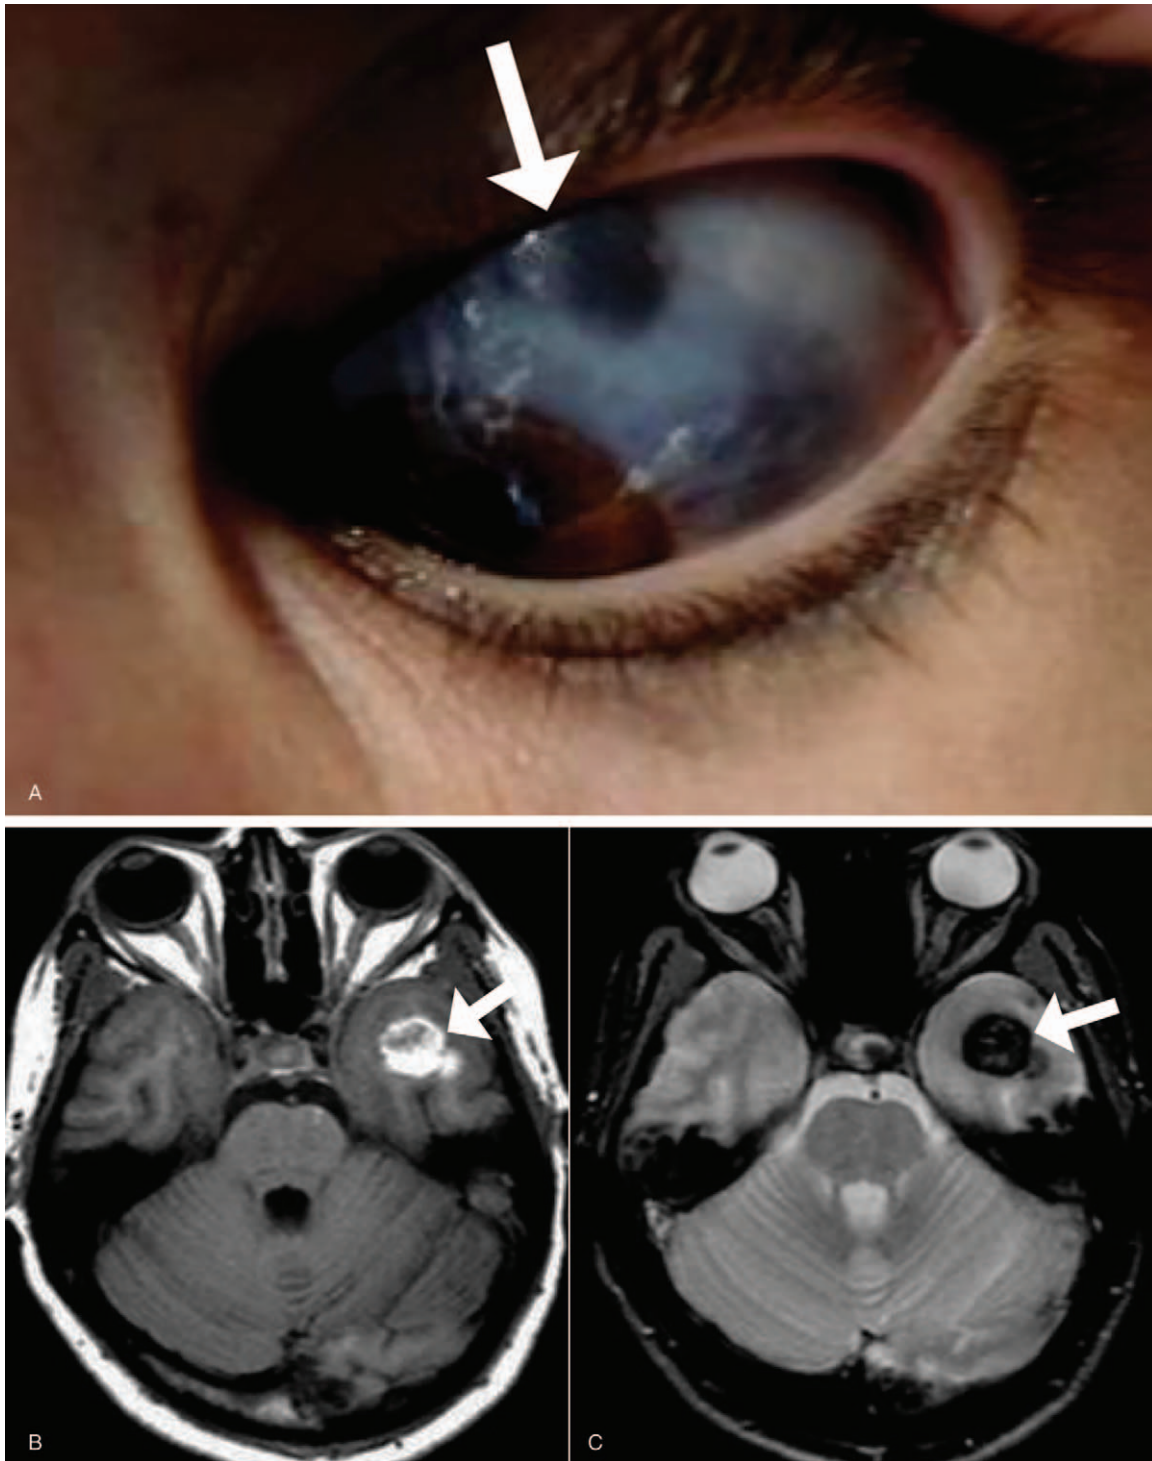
Nevus of Ota. Brownish and bluish areas on the sclera of the left eye (A). Axial unenhanced T1-weighted image (B) and axial T2* (GRE) (C) show a nodular lesion in the left temporal lobe, presenting with T1 signal hyperintensity and marked signal hypointensity on GRE, which may represent melanin deposition and/or blood products (white arrows).
